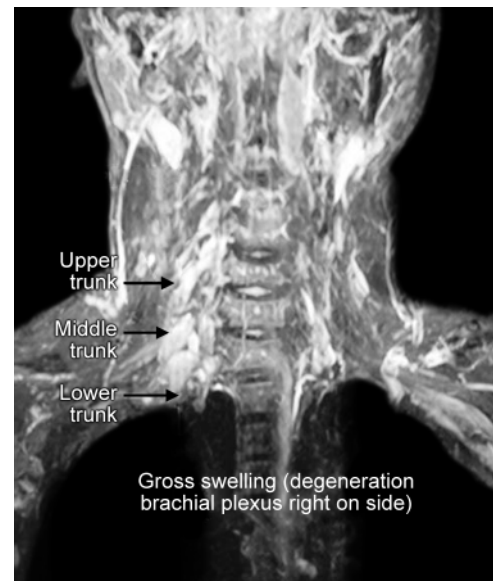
MRI showing right brachial plexus and its derangement
